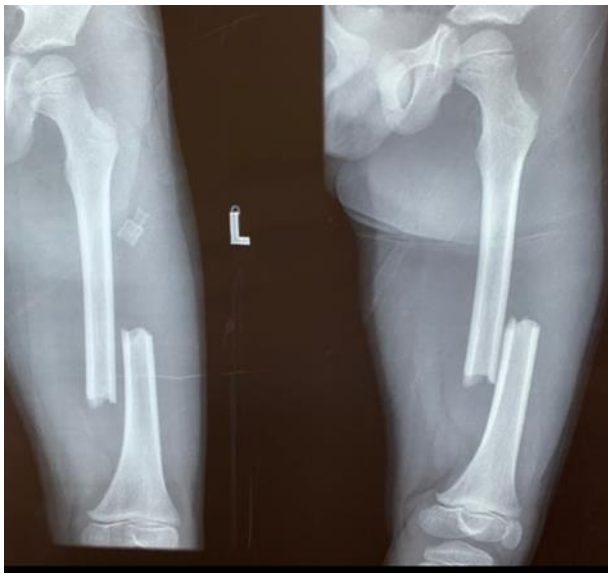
Pre-operative X-Ray images of left femur (Anteroposterior and Lateral View)
